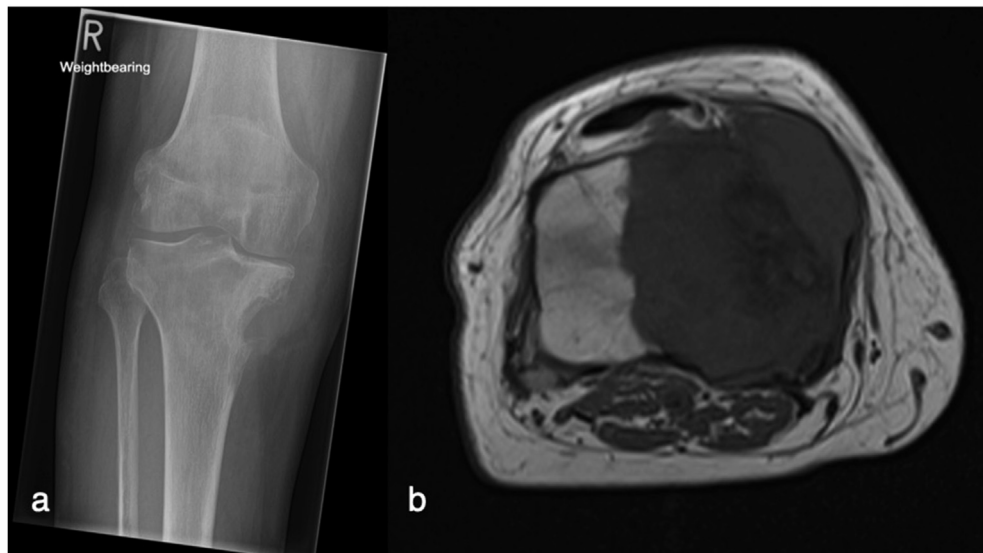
Leiomyosarcoma. AP radiograph of the right knee (a) shows marked periosteal scalloping of the medial aspect of the proximal tibia by a slow-growing soft tissue lesion. Axial T1W image through the proximal right tibia (b) demonstrates a soft tissue mass with osseous erosion. Biopsy revealed a diagnosis of leiomyosarcoma.
